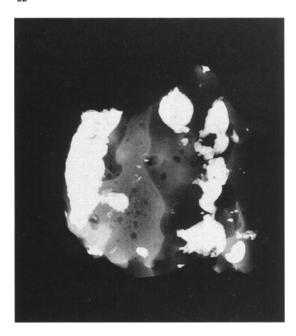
Soft X-ray photograph showing aortic calcification.
